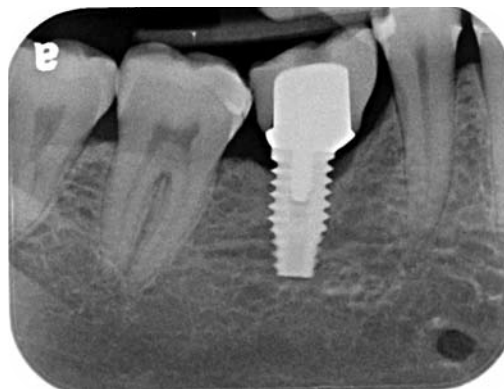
A radiograph showing a zirconia based abutment for an implant with a lithium disilicate crown that has been bonded to it.
